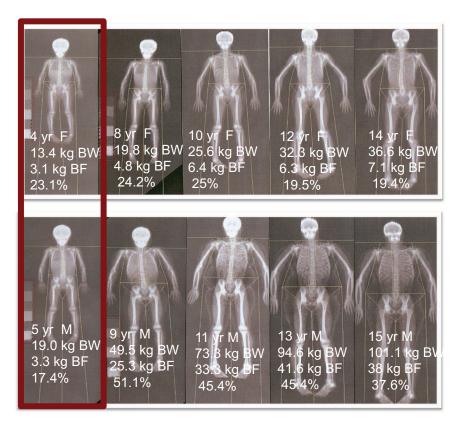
Dual-energy X-ray absorptiometry (DXA) images of two Iowa Bone Development Study participants, a girl (top row) and boy (bottom row), over a 10-year time span.
